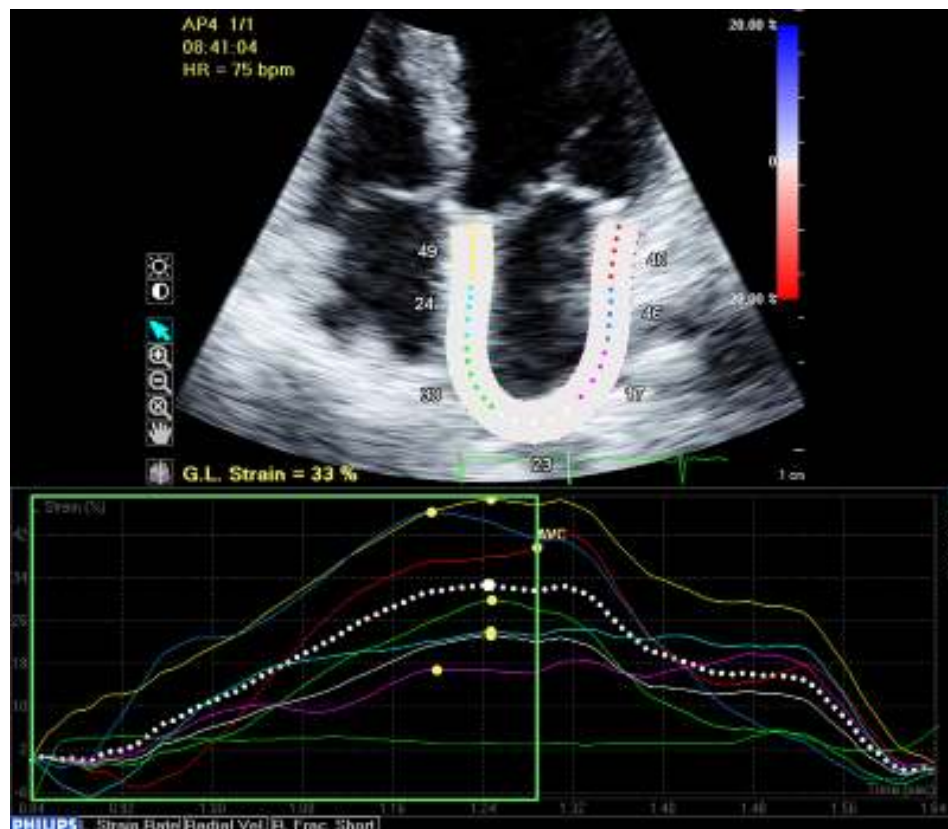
Regional strains are denoted by the colored lines and global longitudinal (G.L.) strain by the white dotted line. The closed circles on each regional strain-time curve identify peak strain. AP4 =apical 4-chamber; AV = aortic valve; AVC = aortic valve closure; HR = heart rate; STE = speckle-tracking echocardiography. ⁽²⁵⁾
